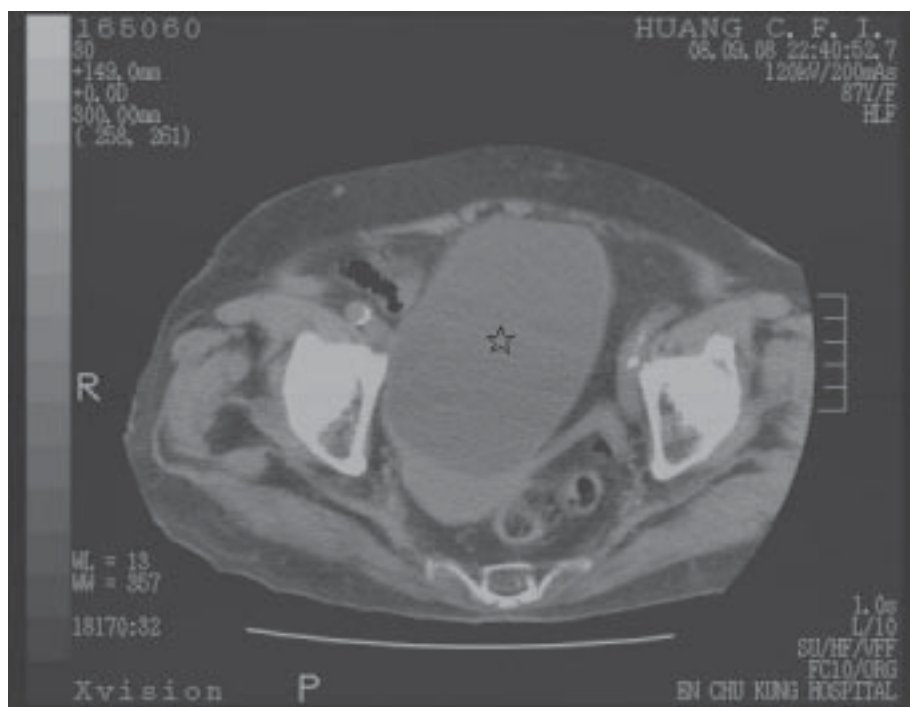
CT scan showed a huge prolate spheroid ovarian cyst (star).
